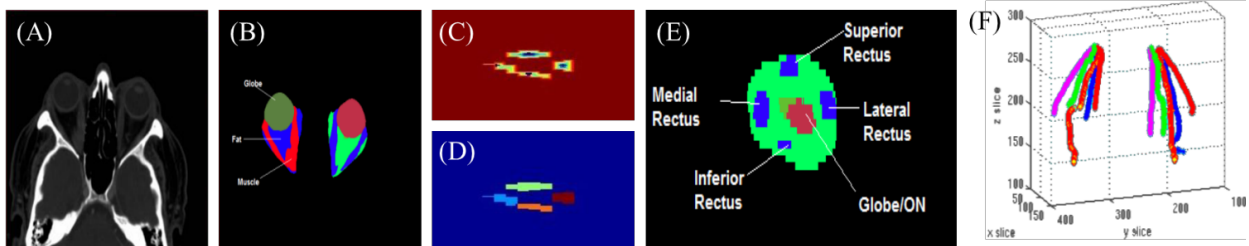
Muscle tracking using Kalman filters: (A) Input CT scan (B) output of label fusion (C) distance transform with imposed maxima (D) measured muscle pieces (E) Coronal view of muscles with respect to landmark (F) the resultant five Kalman filters, for each eye, tracking the muscles. Note that the muscles are well-separated in the front of the orbit (B), but as we approach the back of the orbit there is no longer a clean boundary between them due to inflammation and crowding. The measured positions at each slice are given by a watershed calculation as shown in (C) and segmented in (D). A distance function is calculated over slice z wherein the value of each pixel is given by the distance to its nearest non-zero pixel as shown in (C), creating a contour where there is a maxima at the center of each of the four muscles. At each slice, the algorithm examines the top, bottom, right, and left quadrants for each of the four muscles as see in (E). In total, ten Kalman filters (5 for each eye) are used to track the muscles (F) which results in the 3-D tracks shown in (F).
